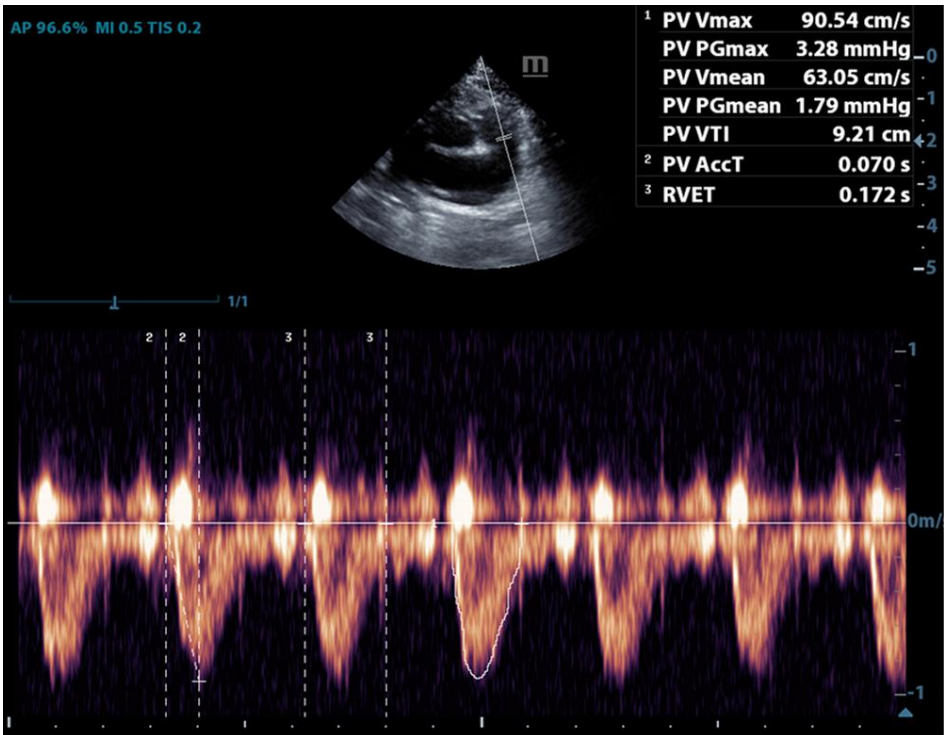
From the right parasternal short axis at the level of the aorta, measurement of echocardiographic Doppler parameters of the main pulmonary artery. Vmax: peak velocity; PGmax: peak pressure gradient; PV AccT: Acceleration time (AT); RVET: right ventricle ejection time (ET). The AT / ET ratio is 0.407 in this rabbit.
